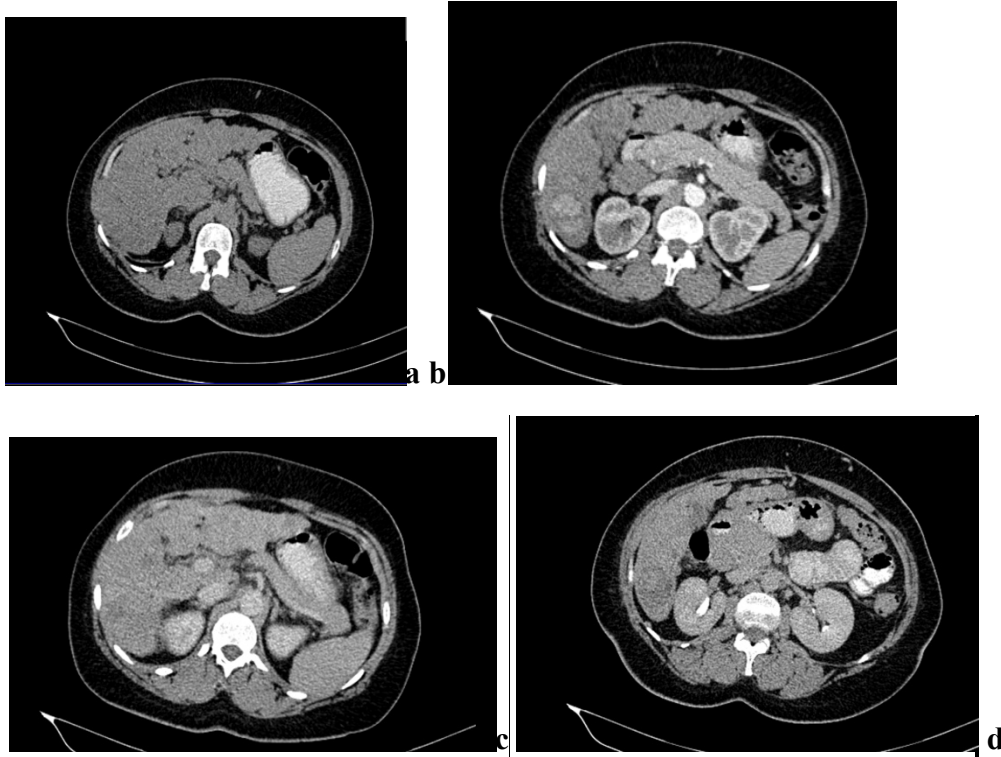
LIRADS 5 Axial CT scan images a-pre-contrast, b-d post contrast; b-arterial phase, c-Porto-venous phase, d-delayed phase. The images demonstrates a nodular surface contour, with a lesion in segment vi which is isodense to the liver in (a), avid contrast enhancement in (b), washout in (c), hypo attenuating (d).
